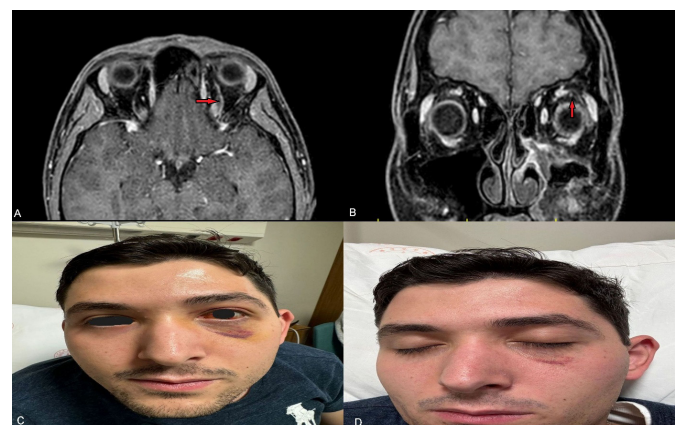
In the first week after treatment; contrast-enhanced computed tomography axial (A) and coronal (B) sections show normal blood flow in the superior ophthalmic vein (red arrow), edema and ecchymosis around the patient's left eye regressed, and proptosis resolved (C, D)
